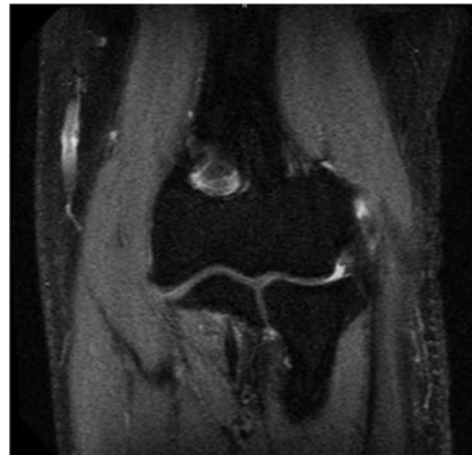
A coronal fat-suppressed T2-weighted pre-treatment MRI showing a partial rupture of the extensor carpi radialis brevis (ECRB) tendon and a plica humero-radialis without impingement in Patient 5.
